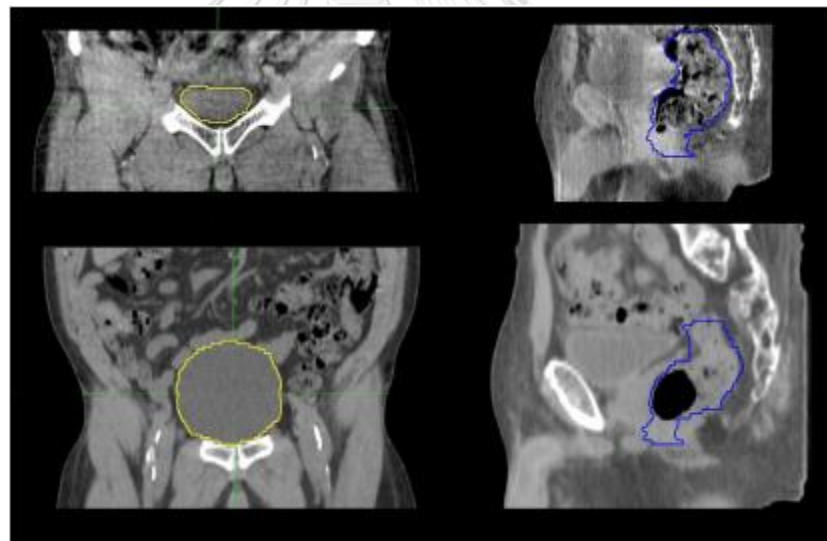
The change in bladder (left) and rectum (right) volume on planning CT (bottom) and daily CBCT
